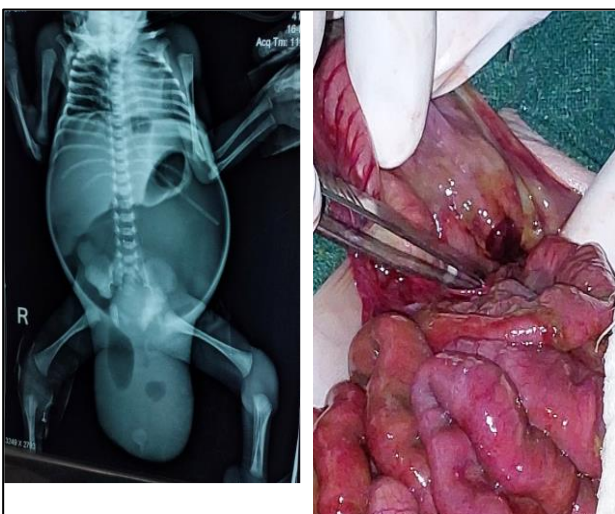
Pre-operative x-ray abdomen with football sign and intra-operative picture showing the perforation in the posterior gastric wall near the fundus.
